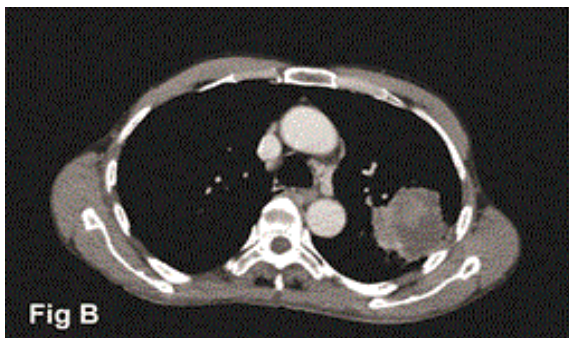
A CT scan cut showing the left upper lobe tumor with suspected chest wall invasion.
